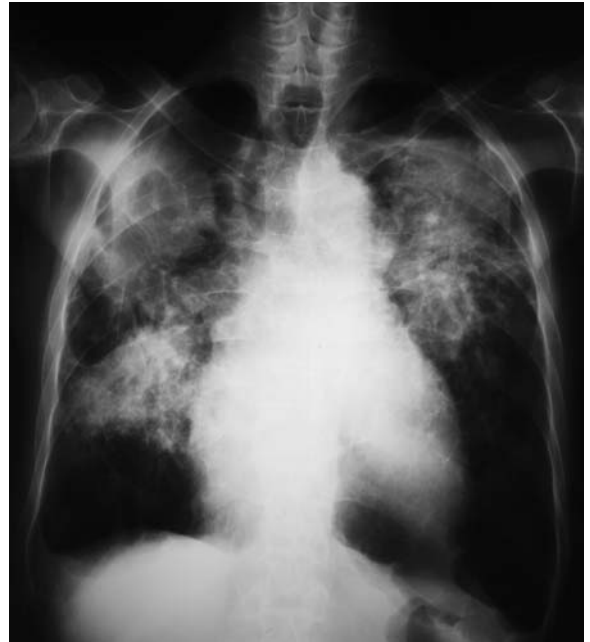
Coal worker's pneumoconiosis: postero-anterior chest radiograph showing progressive massive fibrosis as a large opacity, approximately 6 cm in diameter, in the right upper lung field. Confluence is also visible on the left upper lung field
